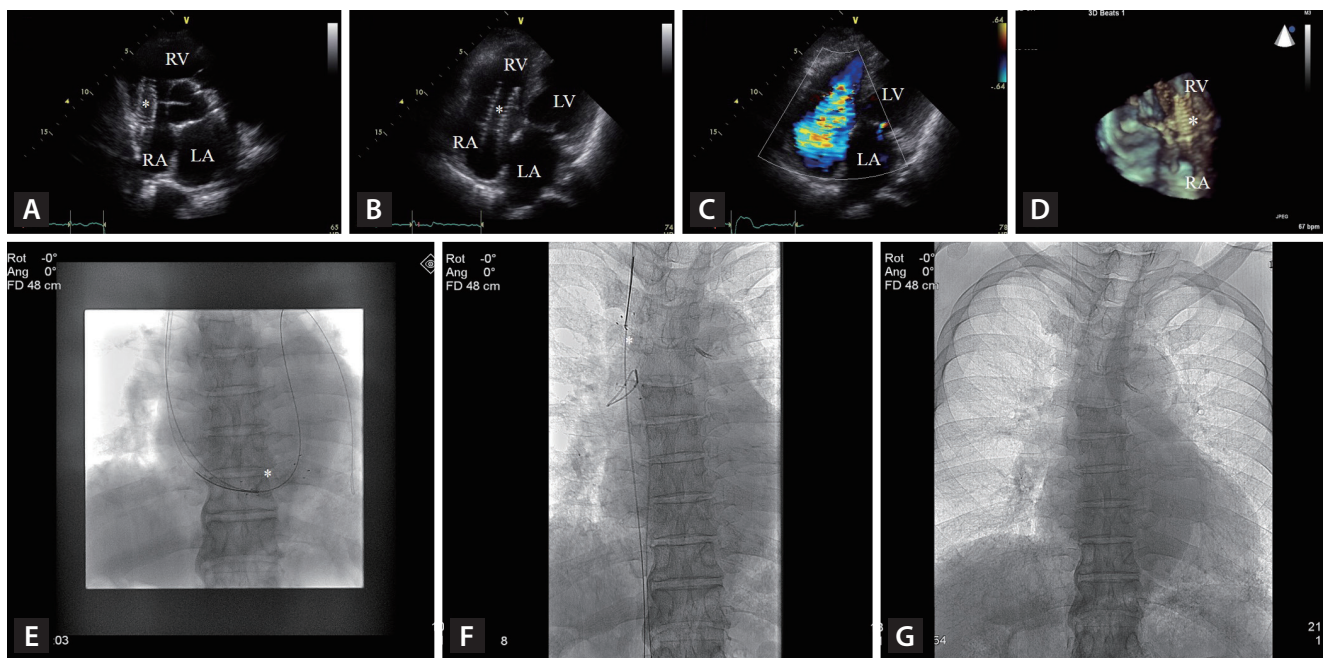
(A, B) Transthoracic echocardiography revealed that a stent (asterisk) was placed in right heart between RA and RV. (C) Modified 4 chamber view with color Doppler echocardiography revealed that the presence of the stent caused severe functional tricuspid regurgitation. (D) The real time three-dimensional echocardiography confirmed the migration of the stent in right heart. (E) The stent was seen in right heart between RA and RV, mostly in RA. The stent was captured with a snare loop from right internal jugular vein. (F) The stent was pulled out into the SVC. The stent in the SVC was captured with another snare from the right femoral vein. (G) The stent was evacuated with another snare from the right femoral vein. LA, left atrium; RA, right atrium; RV, right ventricle; LV, left ventricle; SVC, superior vena cava.
